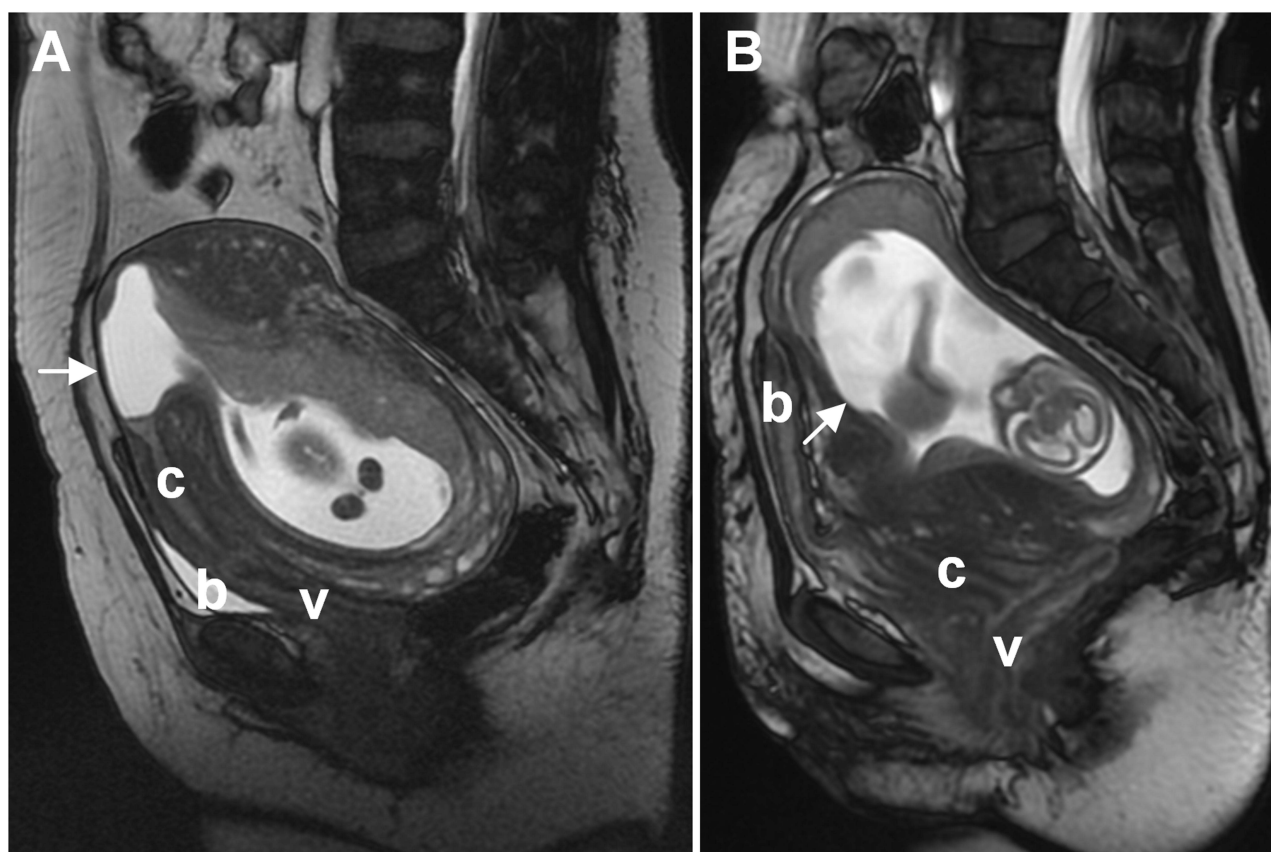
Midsagittal T2-weighted magnetic resonance images of two presented cases. (A) Case 1 at 15 weeks; the white arrow indicates the stretched anterior lower segment of the uterus that was unmeasurable. (B) Case 2 at 16 weeks; the white arrow indicates a cesarean scar niche at the anterior lower segment that was 3 mm at the thinnest point. Abbreviations: b, bladder; c, cervix; v, vagina.
